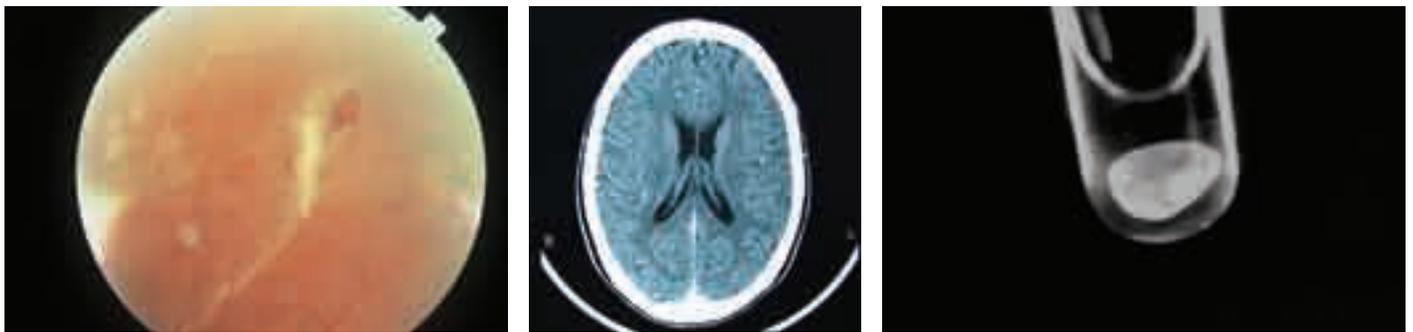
Contraction of fibrous tissue resulting in a linear retinal tear and a combined retinal detachment. Figure 5. CT scan of a patient with neurocysticercosis showing multiple cerebral cysts. Figure 6. An intact cyst of cysticercosis, displaying characteristic features.
